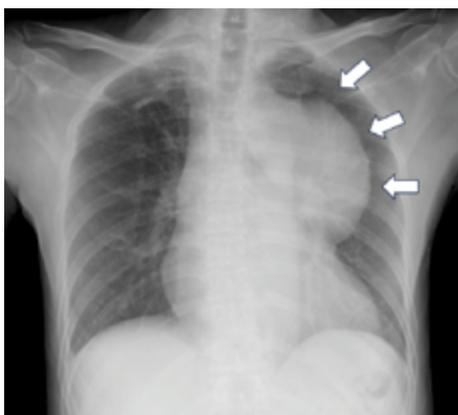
Chest X-ray image of the patient.
